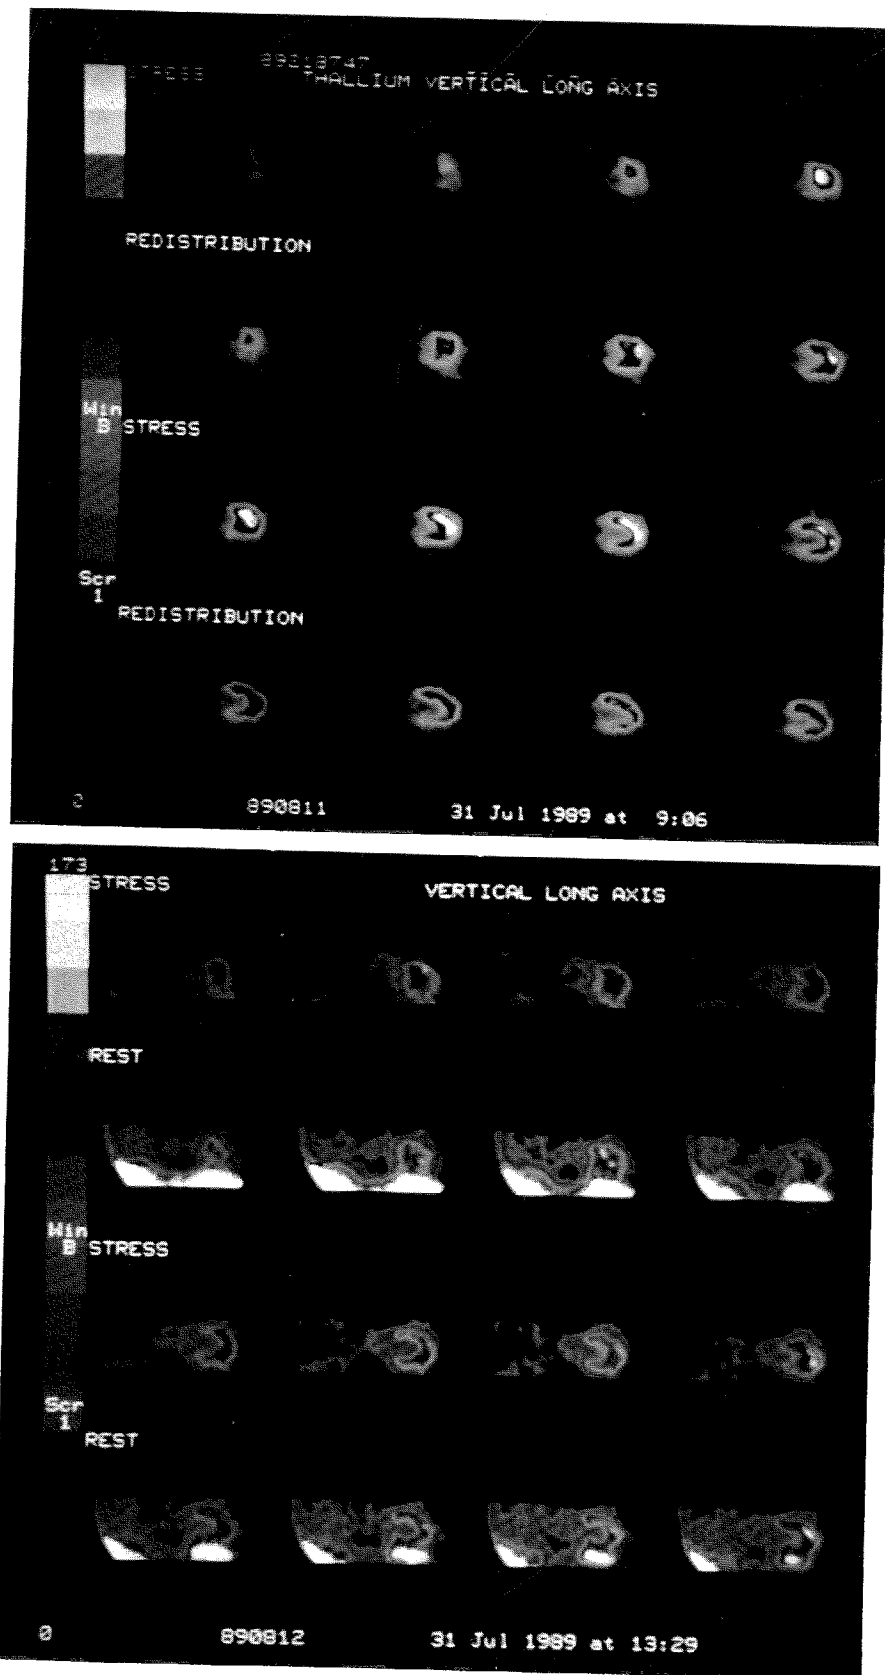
A. Stress and redistribution SPECT images of thallium-201 using reconstructed vertical long axis views. The images are graded qualitatively (on a gray scale) on a continuum from regions of highest tracer uptake (white), to regions of lowest uptake (black). B. Stress and rest SPECT images of technetium-99m teboroxime using reconstructed vertical long axis views. The images are quantitatively graded in a manner identical to the thallium images in A. Note the hepatobiliary uptake of teboroxime on the rest images associated with the relatively short biologic half-life of 5.3 min.
